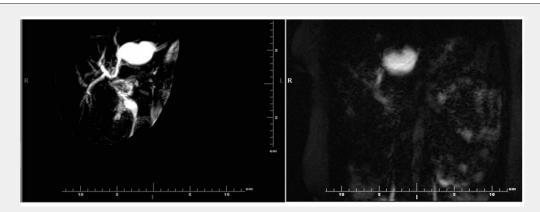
MRI Cholangiopancreaticography showing multi-lobulated inter-hepatic cyst, left lobe of liver.
